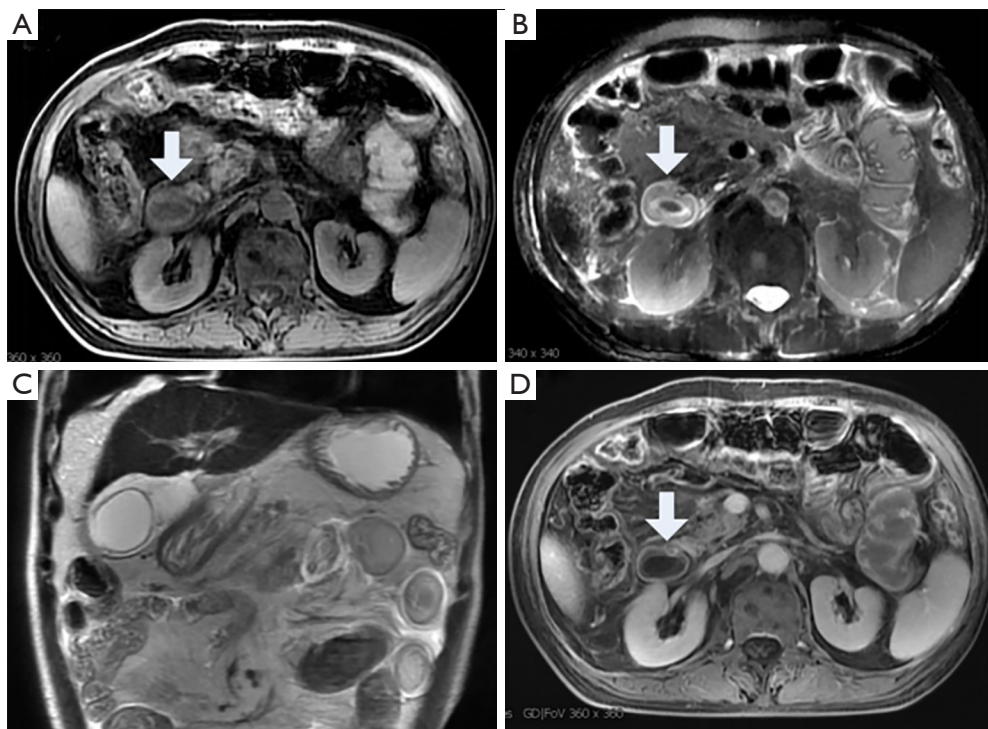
A 44-year-old female with acute pancreatitis. An MRI was performed on the 7th day after the onset of pancreatitis. The duodenum shows thickening on the T1WI (A, arrow). The “target sign“ (arrow) of intestinal wall thickening can be seen on the T2WI (B). The axial (B) and coronal T2WI (C) show dilatation of the duodenum and small intestine, thickening of the bowel wall and edema (arrows). After contrast administration, the signal of the bowel wall was enhanced evenly (D, arrow). MRI, MR imaging.
